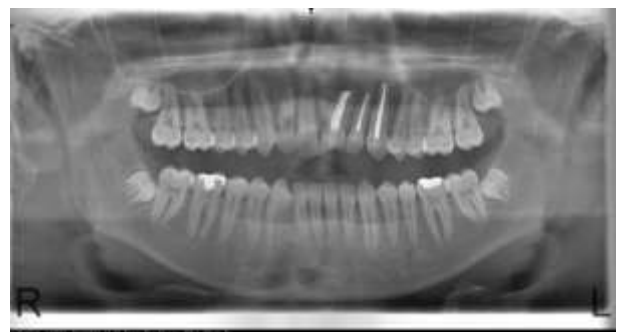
Control Panoramic Radiography after Cystectomy
